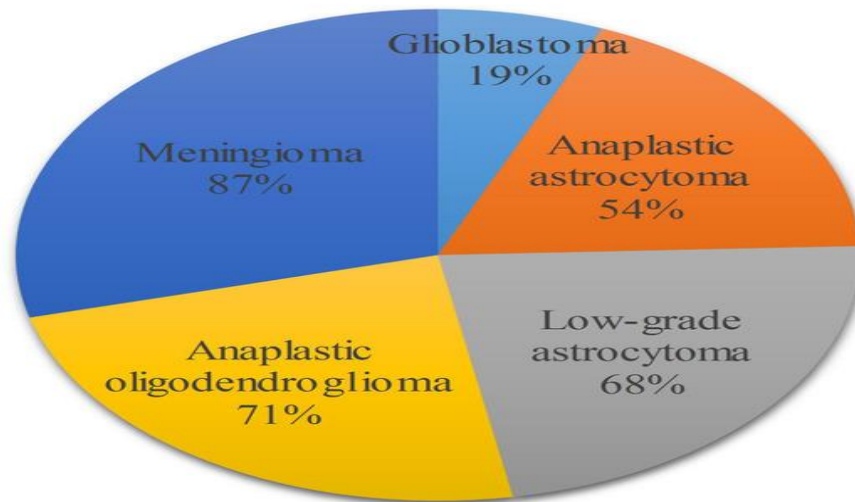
Distribution of classification accuracy across various brain tumor subtypes in MRI-based diagnostic [48].
